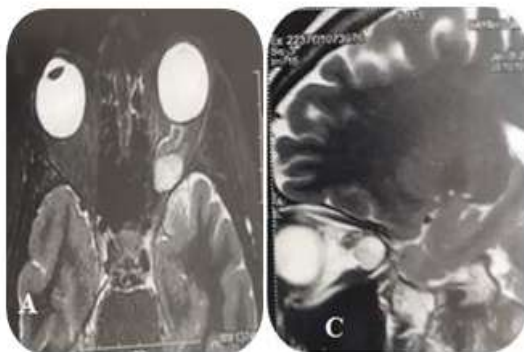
Cerebral MRI in axial A coronal B and sagittal C section: shows an intraconical cavernous hemangioma of apical seat compressing the left optic nerve causing light perception on clinical examination.
